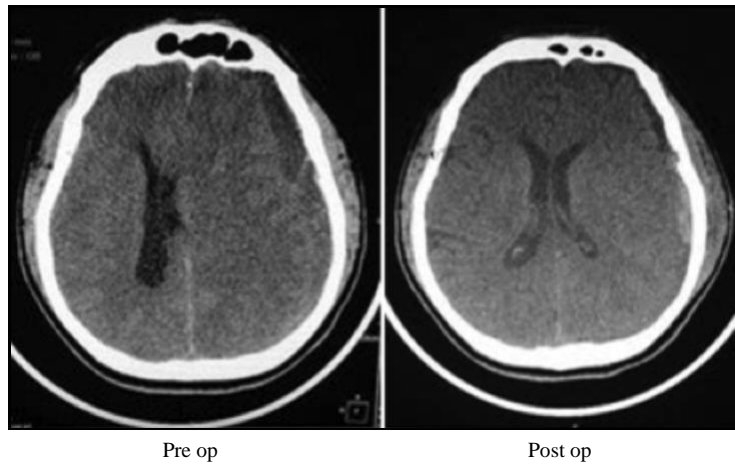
CT brain pre and post operation. The CT brain pre operation showed a left acute on chronic subdural haemorrhage with a midline shift to the right. (left image) After the operation, there was resolution of mass effect and smaller left subdural haemorrhage. (right image).
